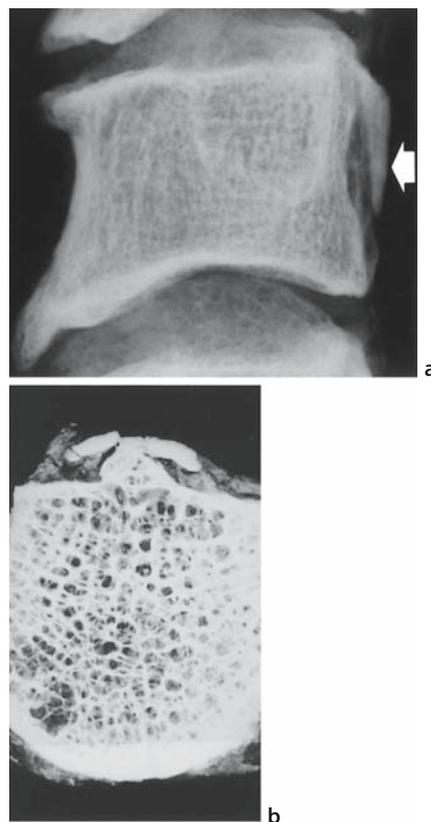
Coexistence of ossification processes in the deep and superficial layers, C4, in a 69-year-old man. *White arrow* in a indicates the level in b. See text for details. Note the differences in the radiographic densities of the ossification of the deep layer between lateral and cross views. (From Tsuzuki et al. [6], with permission)
